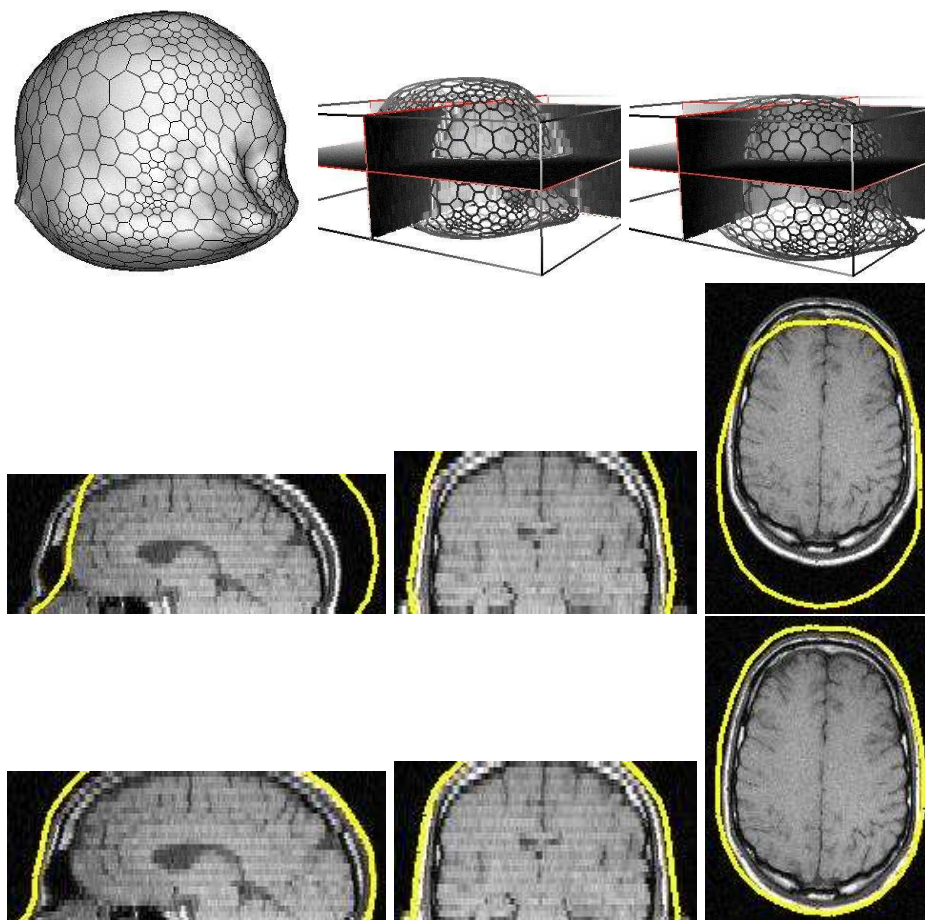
CT-T1 registration. Top line: face model reconstructed from the CT image, model embedded in the MR image, and model registered. Middle line: intersection of the model with 3 planes of the MR image before registration. Bottom line: intersection of the registered model with the same 3 planes after registration.
